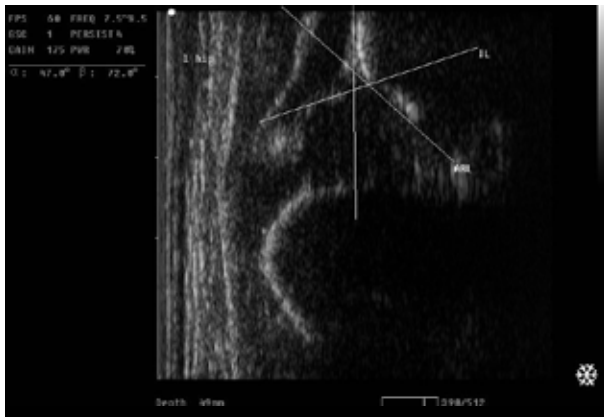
Sonographic image of infant with α -angle = 47° and β -angle = 72°, type IIc in Graf classification
